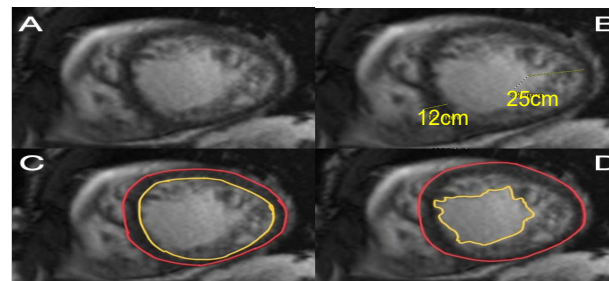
Cardiac MRI A short axis view left ventricle; B maximal left ventricular noncompaction:compaction ratio of 2.1-2.2:1; C epicardial and endocardial contours; D epicardial and noncompacted contours.
